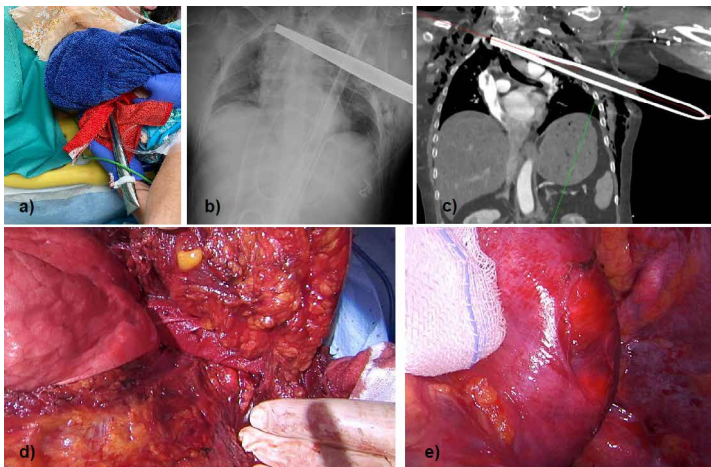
a) Penetrating swiss flagpole b) Initial chest x-ray c) whole body CT d) Flagpole penetrating the left upper lobe e) Aortic arch
